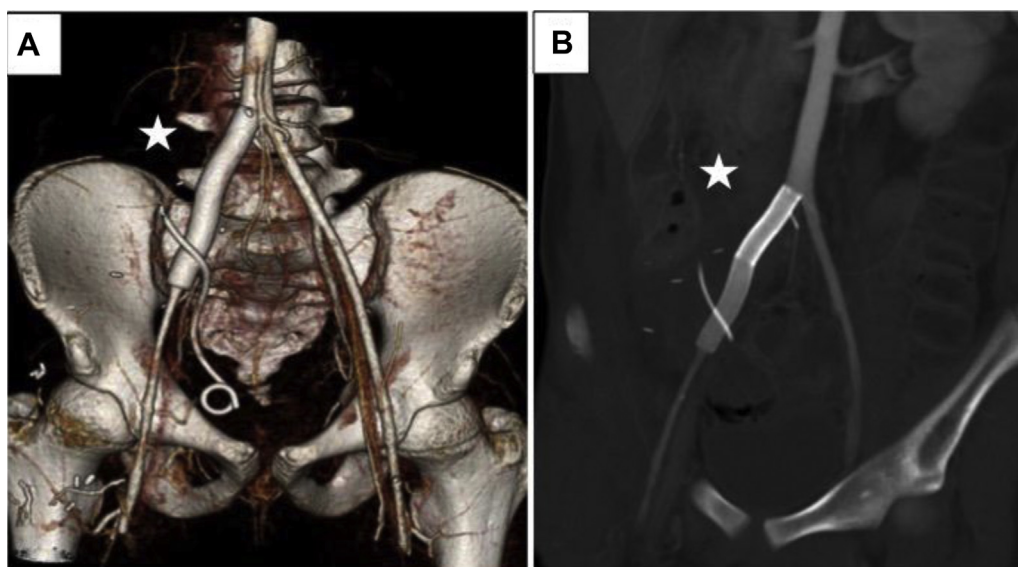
Computed tomography (CT) angiography 2.5 months after repair. A, Three-dimensional reconstruction demonstrating patent stent graft. B, CT angiography with patent stent graft. *Star* marks the stent graft.
